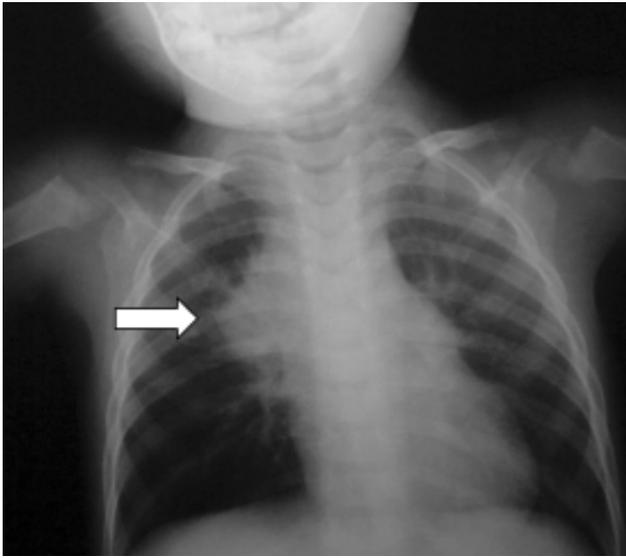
Chest radiography. Hyperinflated right lung with perihilar lymphadenopathy (arrow).
